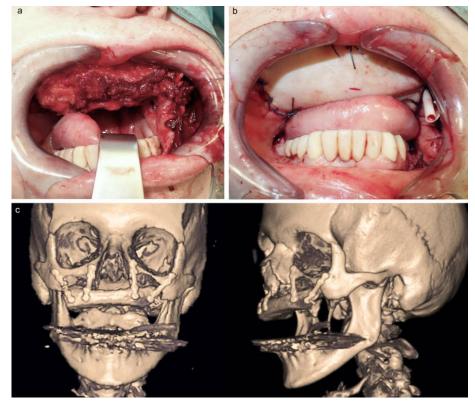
(a) Insertion of a DCIA flap with an extended muscle cuff for bony reconstruction and internal lining and (b) a free fasciocutaneous radial flap for intraoral coverage. (c) 3D-CT scans of postsurgical DCIA flap position
